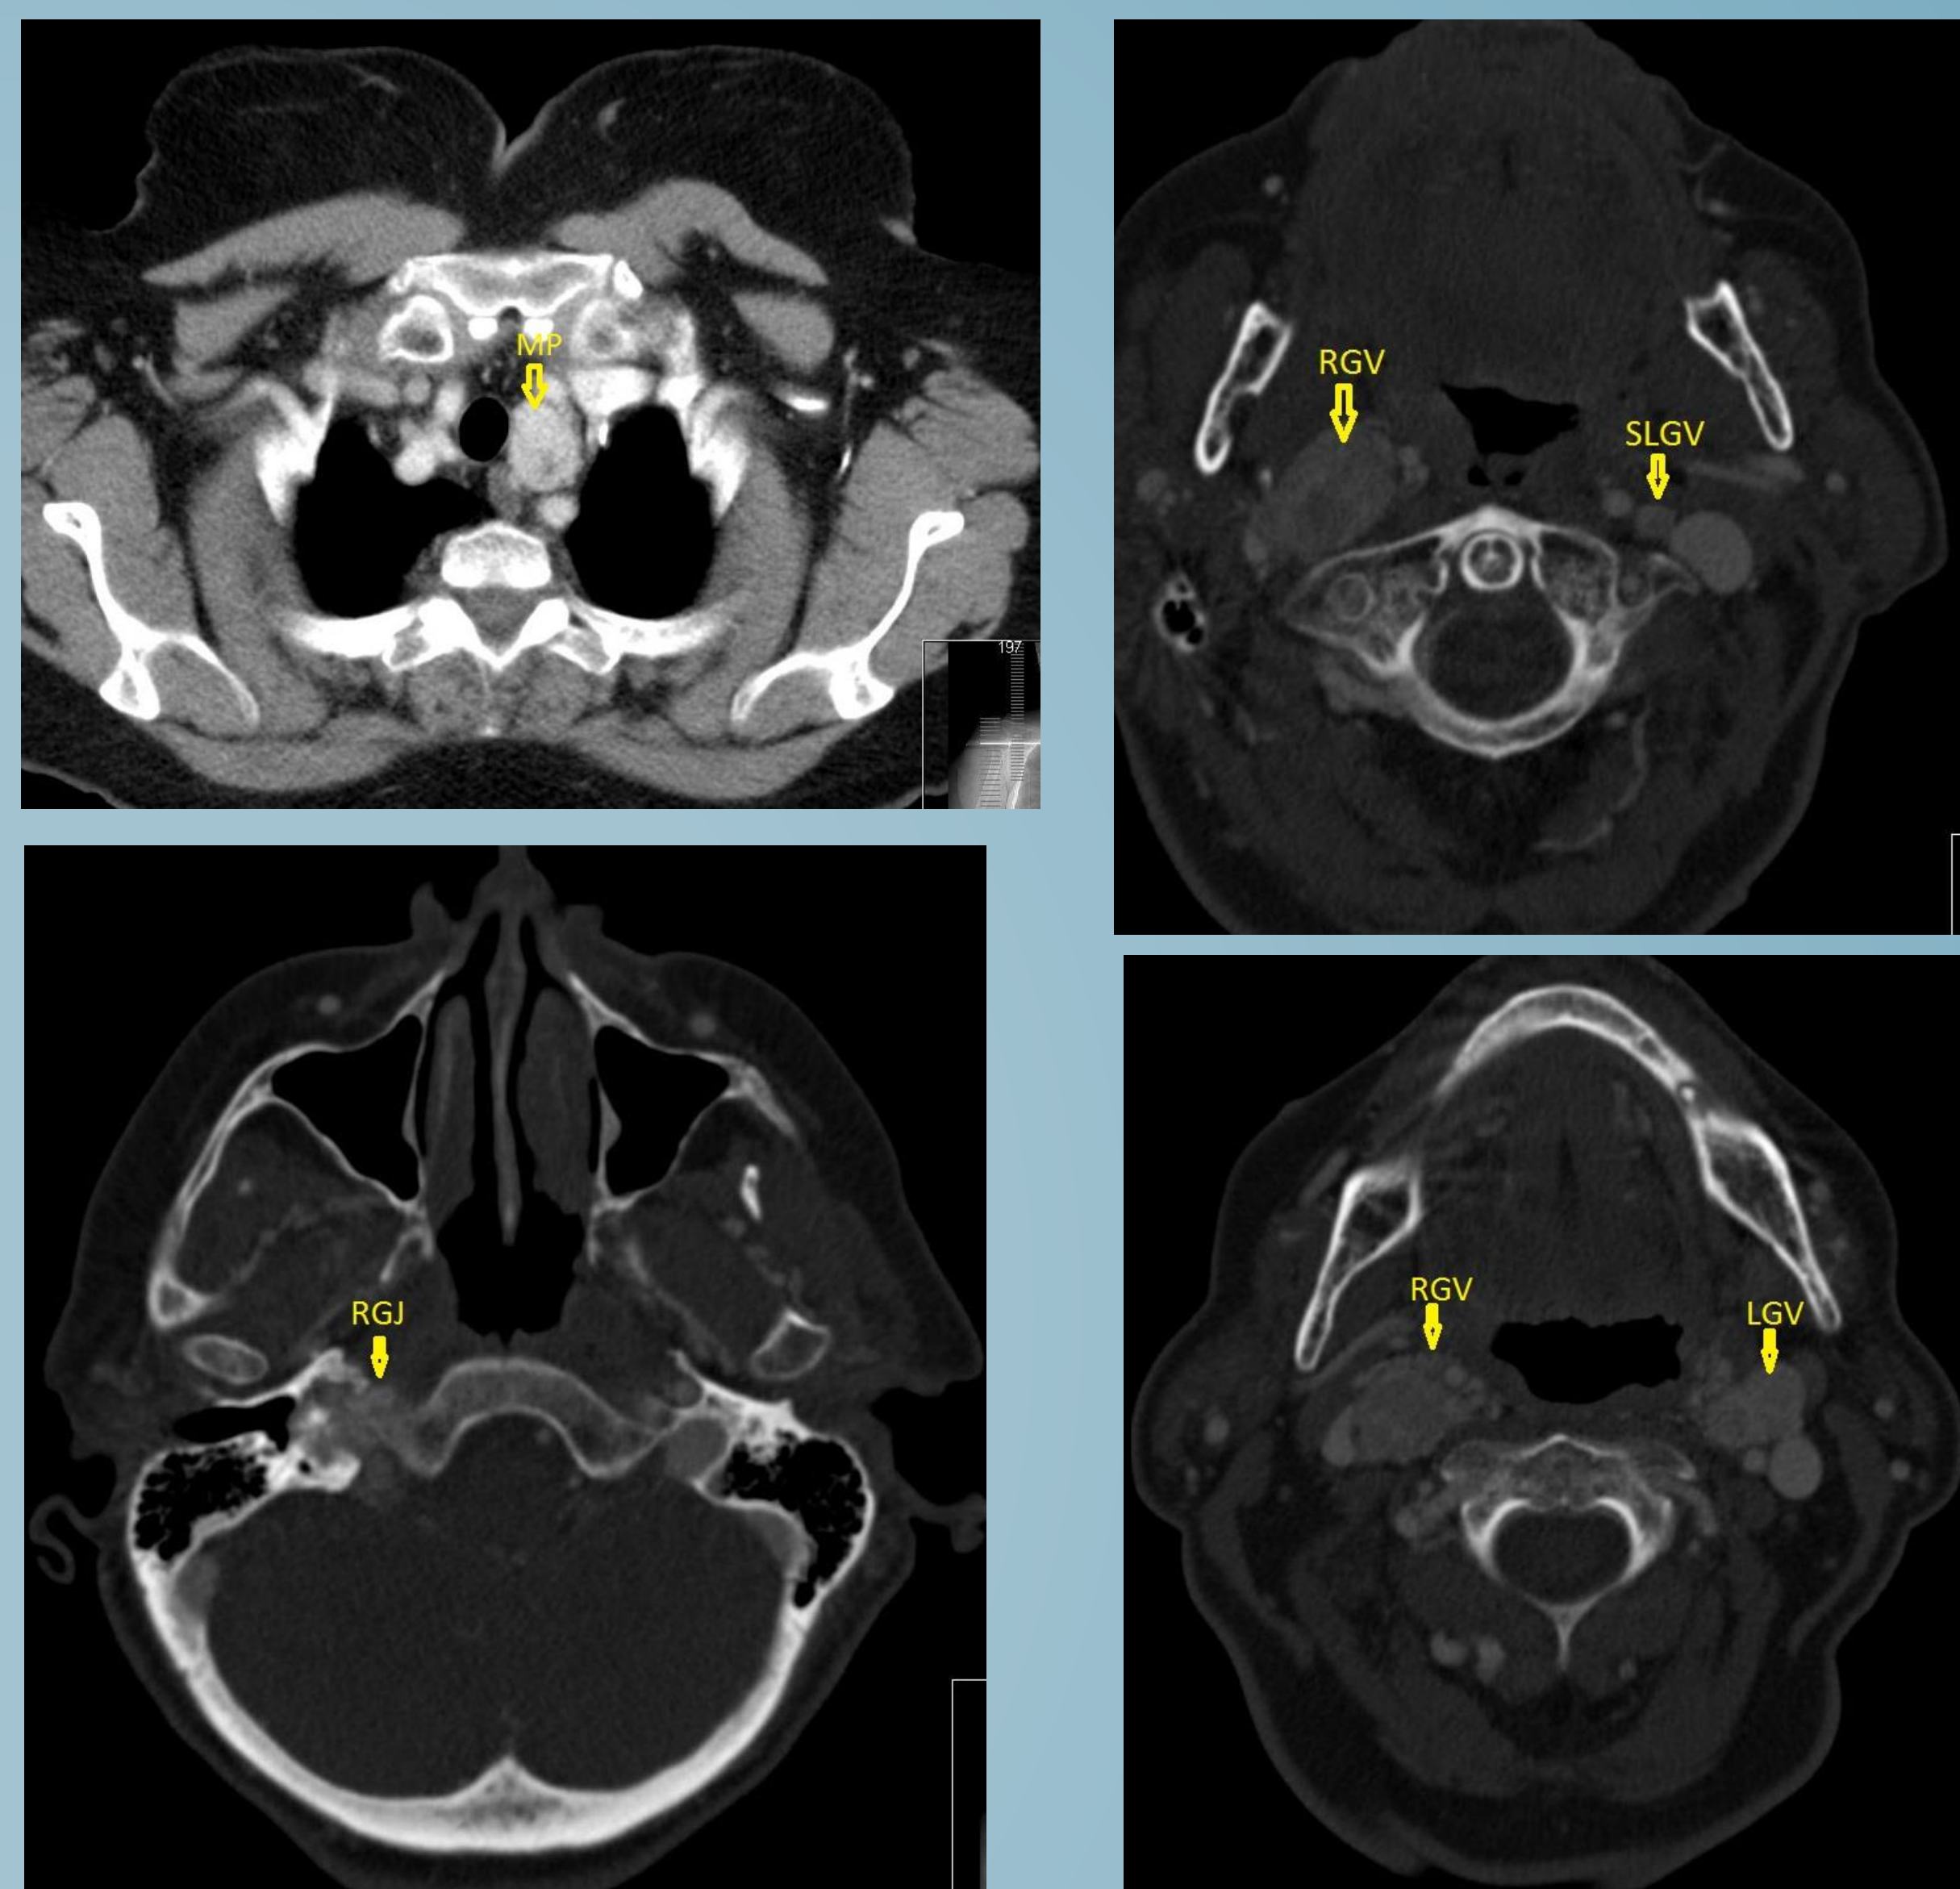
Axial CT neck and chest with contrast showing superior mediastinal paraganglioma (MP) between the proximal left common carotid and subclavian arteries, right glomus vagale (RGV) extending to a point just above carotid bifurcation with the carotid artery displaced anteromedially, a lower left glomus vagale (LGV) and a smaller left glomus vagale (SLGV) high in the neck.
